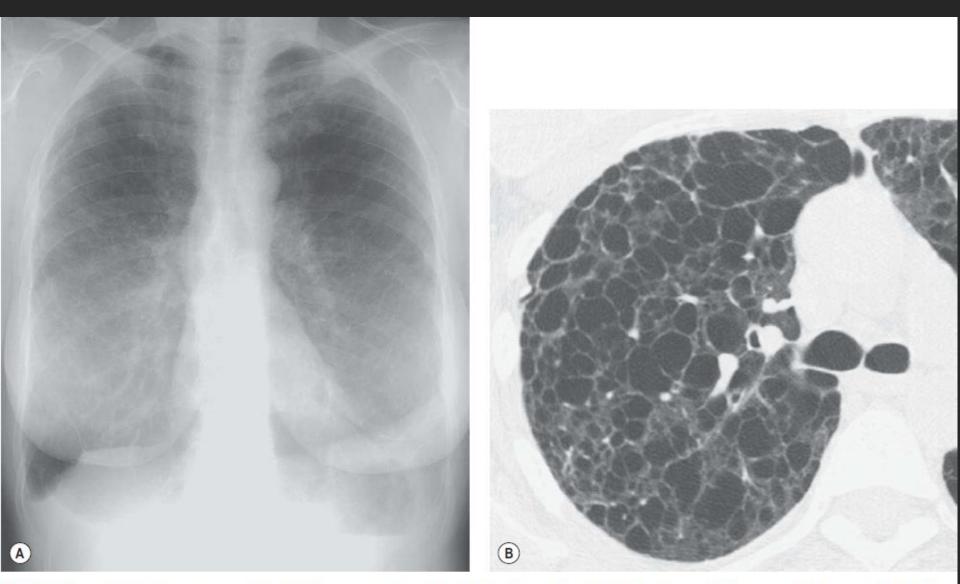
A 54-year-old woman with LAM. A, Chest radiograph shows marked hyperinflation with a diffuse coarse reticular pattern. There is a small left effusion. B, CT shows profuse round cysts, each with a well-defined thin wall. The cysts are so numerous that they appear clustered.
